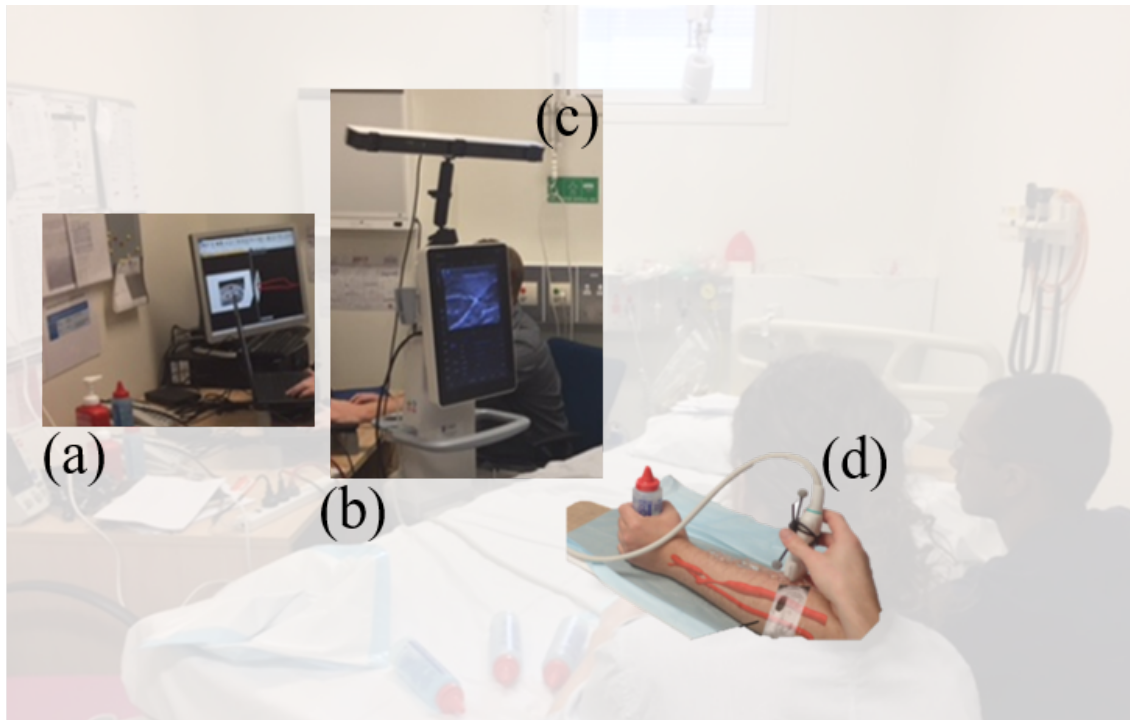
Set-up for the clinical patient scans performed for data collection with two personnel, one to perform the ultrasound scan of a patient and the other tasked at the workstation. (a) The workstation laptop (b) Mindray, TE7 Ultrasound machine, (c) Optitrack V120: Trio camera and (d) Mindray L14-6NS, 14MHz, 38mm FOV linear ultrasound transducer, with a rigid body attached to it [153].
